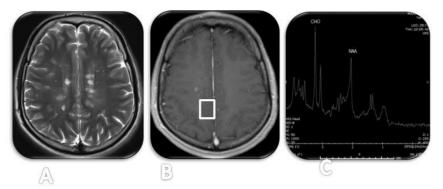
Transverse MRI sections T2WI, (A) T1CE, (B) showing bilateral MS plaques in the frontal and parietal white matter with enhancement in the right parietal region. (C) MRS showing a decrease in NAA levels and an increase in choline and lipids levels indicating areas of acute demyelination.
